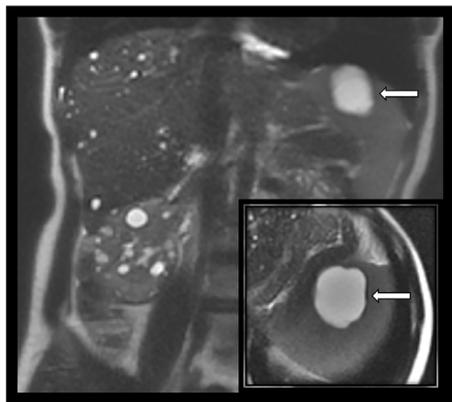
A 32-year-old woman with ADPKD (PKD 1 mutation). Coronal T2-weighted image shows a 44 mm spleen cyst (white arrow). Axial T2-weighted image (inset) confirms that it is arising within the spleen.
